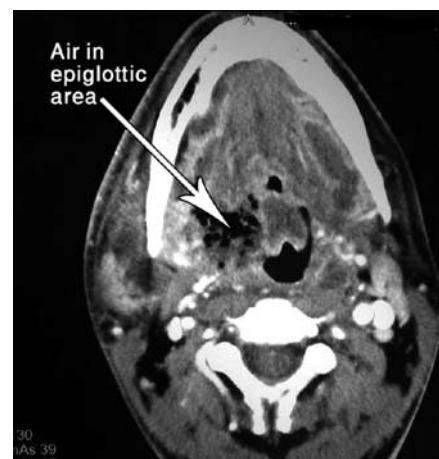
Axial neck CT post-contrast shows right parapharyngeal air extending medially to the epiglottic area and glottic area.
